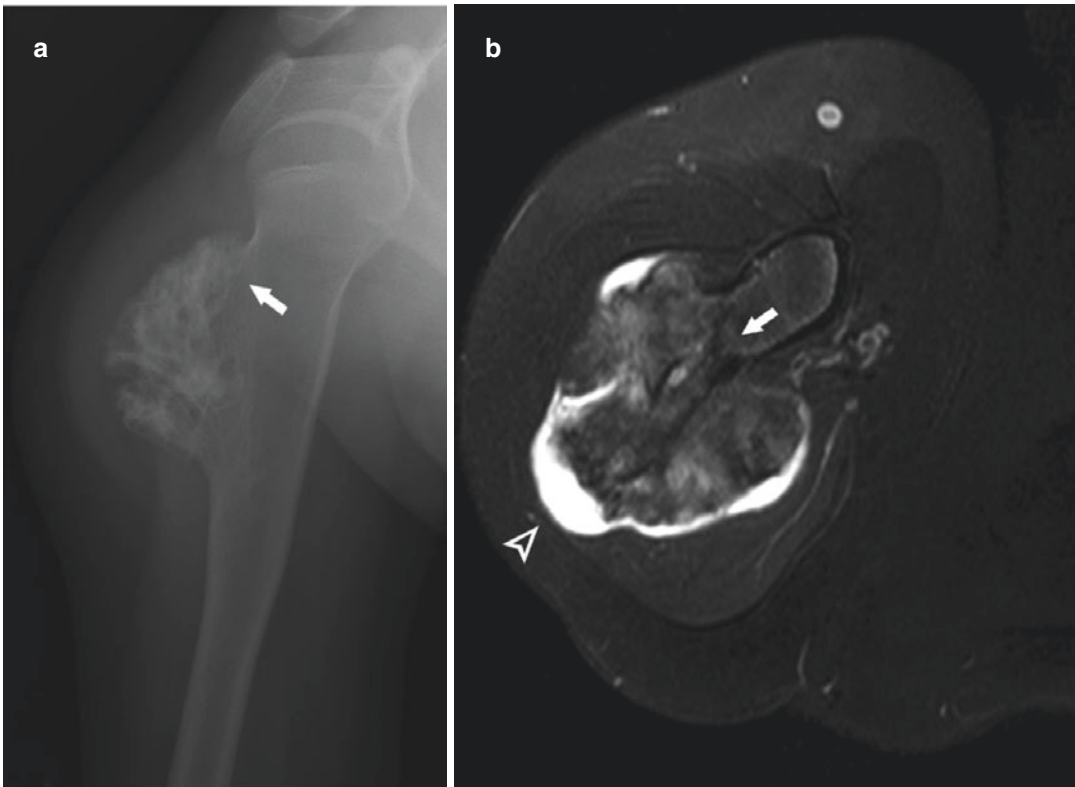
Osteochondroma: 13-year-old male with upper arm pain. Radiograph (a) and axial T2-weighted (TR3250, TE70) image (b) with fat saturation demonstrate an exophytic mass (sessile osteochondroma) with cortical and medullary continuity (arrows). Typical chondroid matrix
